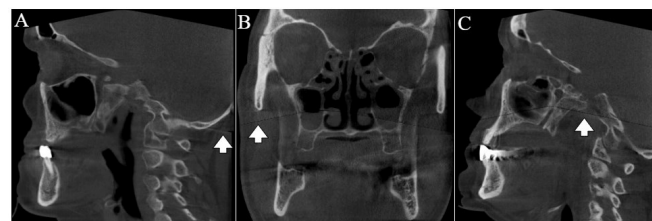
Stitched artifact (white arrows) is indicated in the sagittal (A, C) and coronal (B) CBCT images.
